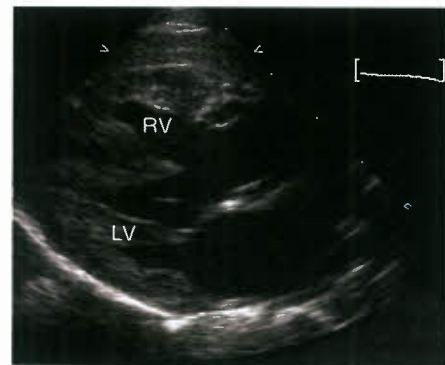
Parasternal long-axis view demonstrating a malalignment VSD associated with tetralogy of Fallot. There is anterior deviation of the interventricular septum resulting in aortic override of the VSD.
